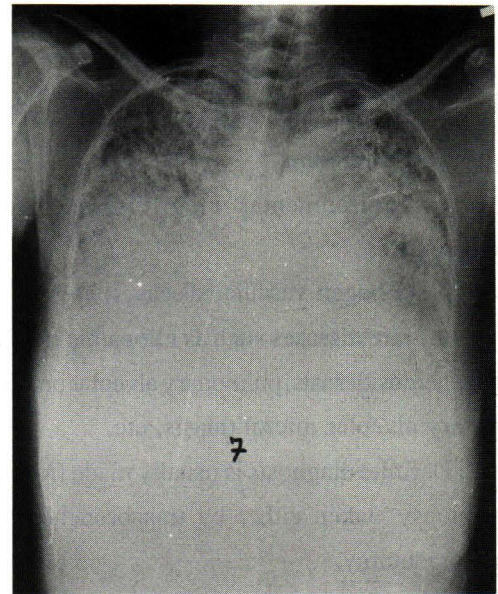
Chest radiograph showing dense miliary shadows, particularly in the lower lung zone with some area of fibrosis.
